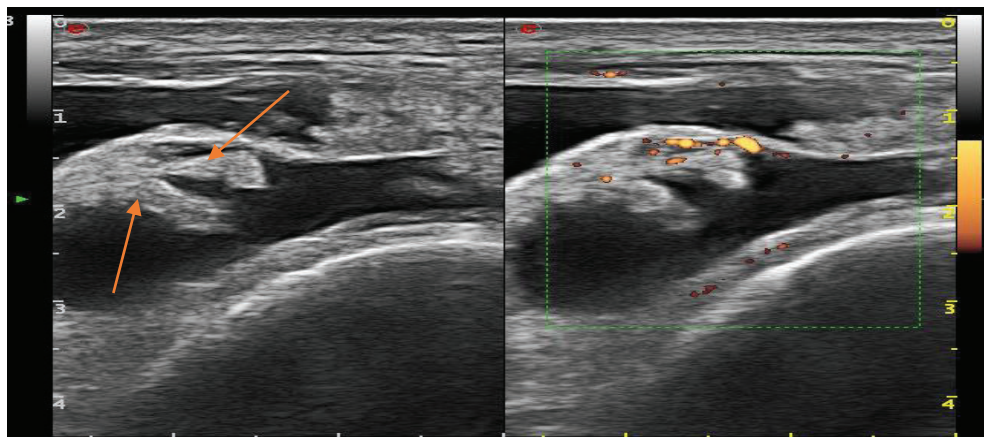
Right knee, longitudinal section in two-dimensional mode and power Doppler mode through the sub-quadricipital recess, hypo-echogenic fluid effusion containing numerous villo-nodular formations (red arrows) picking up the Doppler in places
